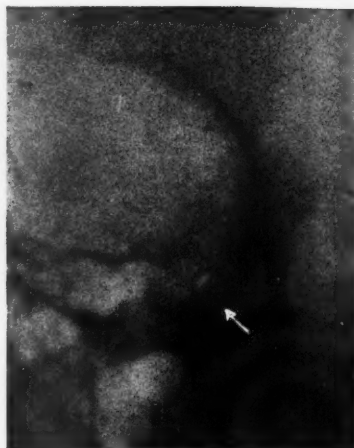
Roentgenogram of the optic canal after the method of Rhese-Goalwin. Indentation in the lower portion of the optic canal (a variation?).
